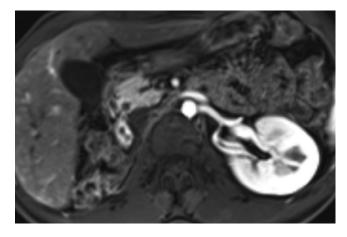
Axial T1 weighted MR image shows a normal pancreatic head but no neck, body or tail region, compatible with complete dorsal pancreatic agenesis. The rest of the pancreatic bed is occupied with bowel loops. There is no dilatation of the ventral Wirsung duct. Only the left kidney is present.
